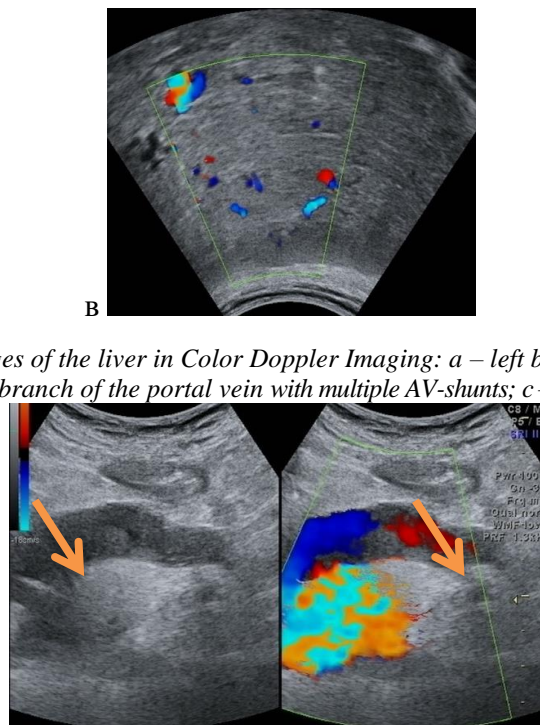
Ultrasound image of a mural thrombus in the superior mesenteric vein (indicated by the arrow) in Color Doppler Imaging
